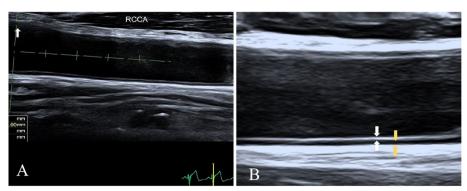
A Ultrasound examination of the right carotid artery by 24 MHz probe. B The carotid intima thickness (white arrow), the carotid media thickness (yellow arrow)
